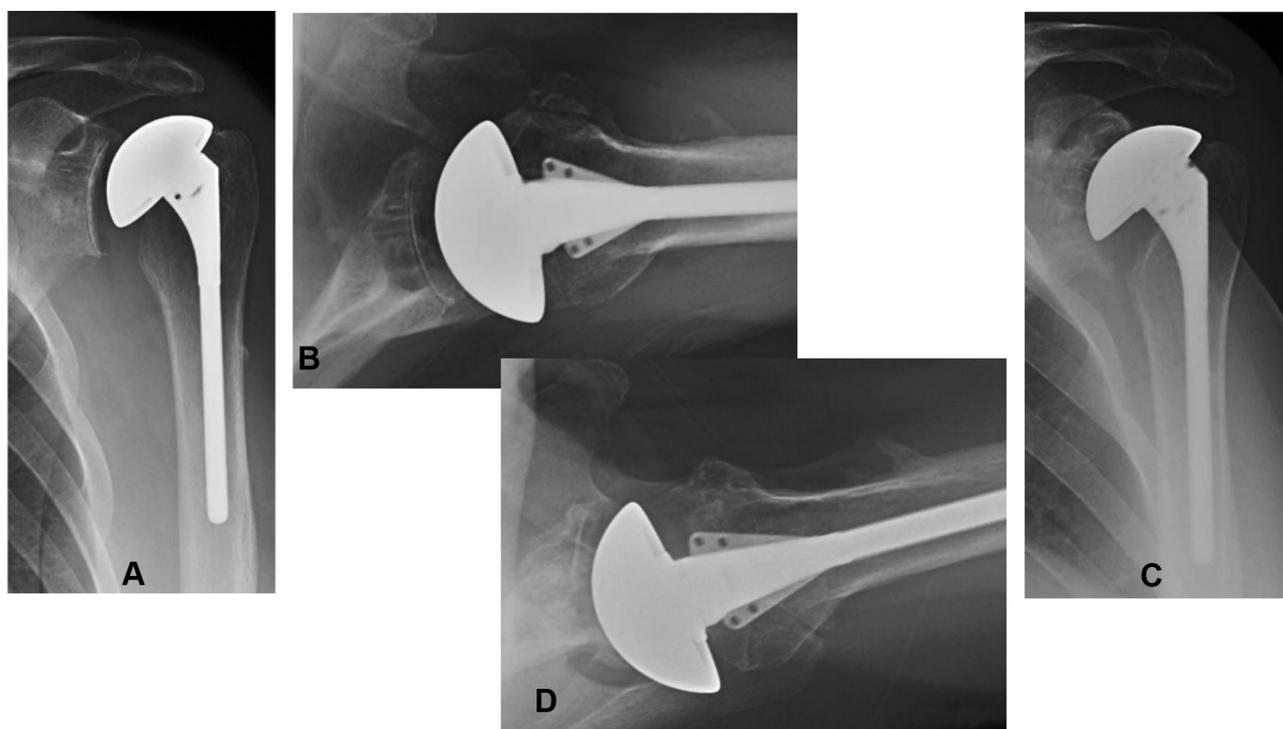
Anteroposterior (A) and axillary lateral (B) radiographs of a 70-year-old male patient 3 months after surgery. Comparison anteroposterior (C) and axillary lateral (D) radiographs at 88 months demonstrating a significant progression to grade 3 medial calcar resorption.
